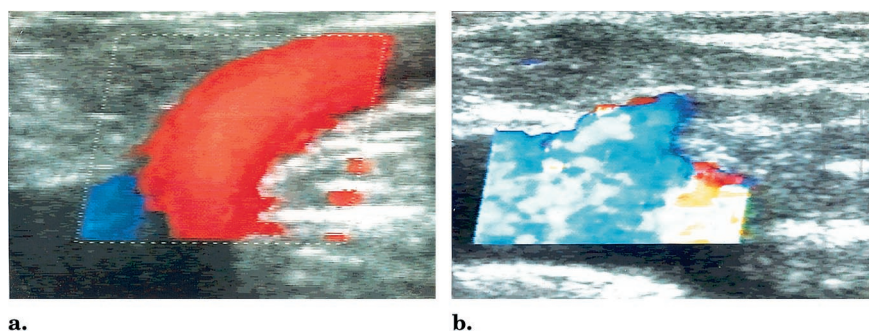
Color Doppler examinations (longitudinal views) of the GSV at the SFJ demonstrating successful occlusion after endovenous laser treatment. (a) Pretreatment evaluation demonstrates an enlarged GSV with reflux after distal calf compression; (b) 1-year follow-up examination shows typical "cul-de-sac" appearance of the proximal GSV with occlusion of the treated segment.
